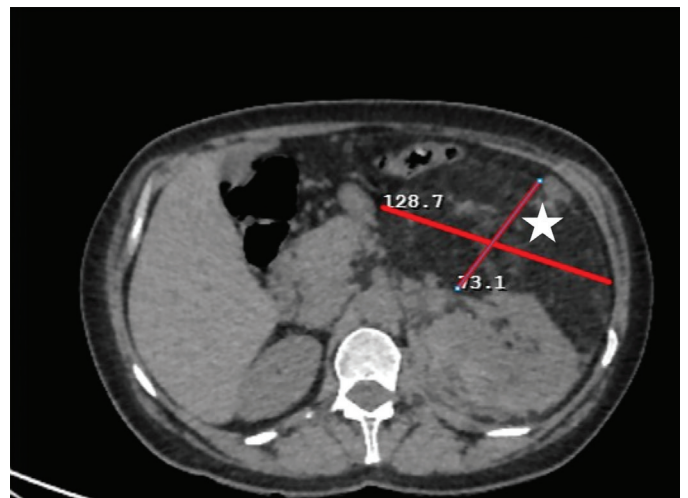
In the non-contrast abdominopelvic computed tomography examination; it demonstrates a mass consistent with angiomyolipoma, originating from the left kidney, with approximate dimensions of 15 cm in length, well-defined, lobulated contours, and containing dense fatty content (indicated with a star)
